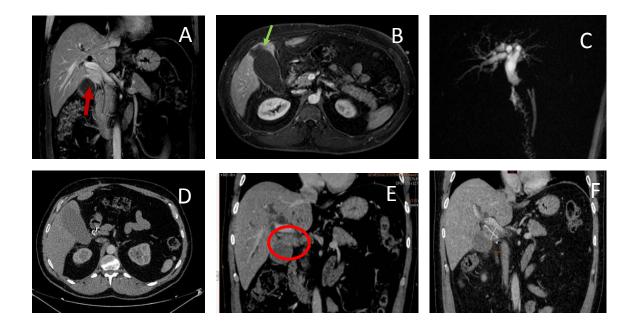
A. MRI Imaging showing focal hepatic lesion trapping the bile duct (red arrow). B. focal hepatic lesion adjacent to the gallblader fundus (green arrow). C. MRCP shows Bile duct dilation with stenosis of the common bile duct. D.E. CT scan shows disappearance of the gallbladder fundus lesion and stability of the infundibulum lesion after treatment (red circle). F. Disease progression, with an increase of the infundibulum tumor volume.
